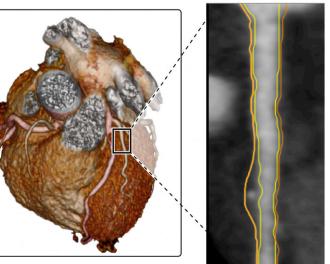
Psoriasis and noncalcified coronary artery disease by coronary computed tomography angiography. A, A patient with psoriasis undergoing a CT scan. B, A 3D reconstruction of the coronary artery obtained from a coronary computed tomography angiography scan of the patient with psoriasis. C, Planar reconstruction of the coronary artery obtained from coronary computed tomography angiography. The orange line represents the outer border (total volume), and the yellow line represents the inner border (lumen volume). *3D*, 3 Dimensional; *CT*, computed tomography.
